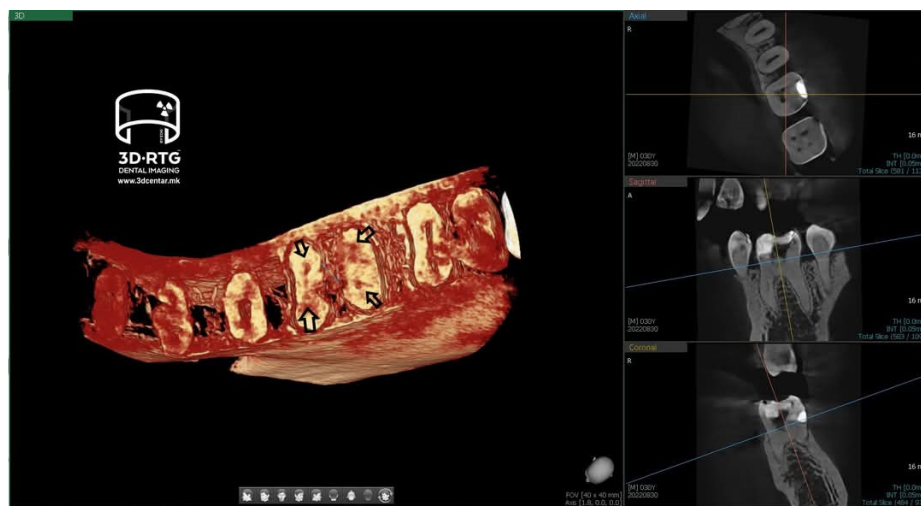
3D CBCT analysis of a lower left molar where horizontal cross-sections of segments show the presence of calcifications in the ventricular part, visible canal obliteration in the root canals
